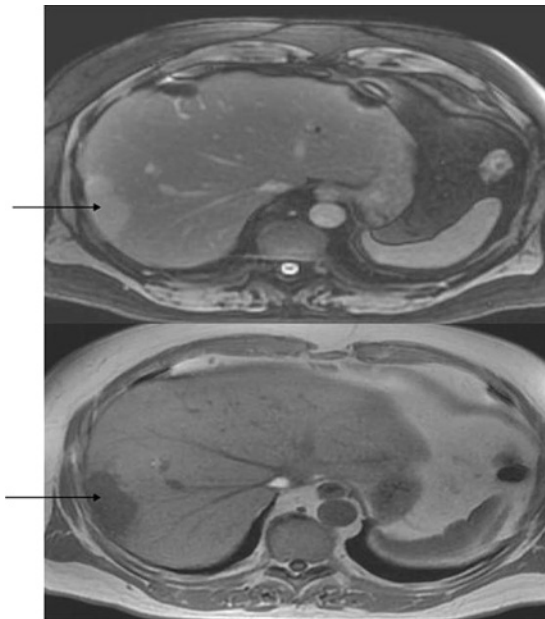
T2-weighted (upper picture) and T1-weighted magnetic resonance image of right lobe hemangioma.
